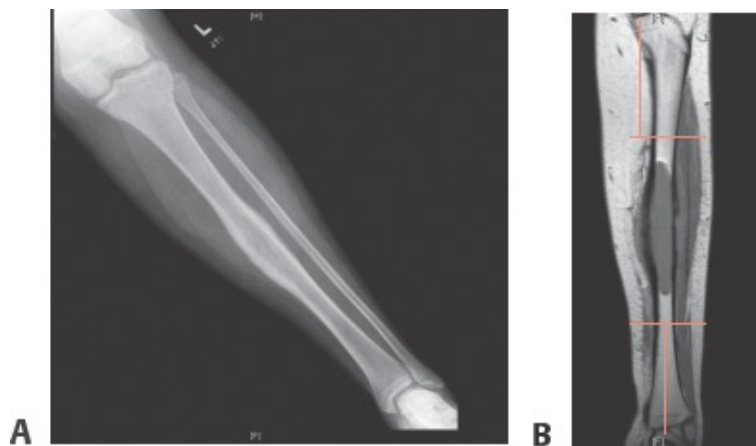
• A. Anteroposterior radiograph of a 16-year-old girl with a midtibia Ewing sarcoma. B. Sagittal T1-weighted MRI demonstrating the intramedullary extent of the tumor and measurements for bone resection.
